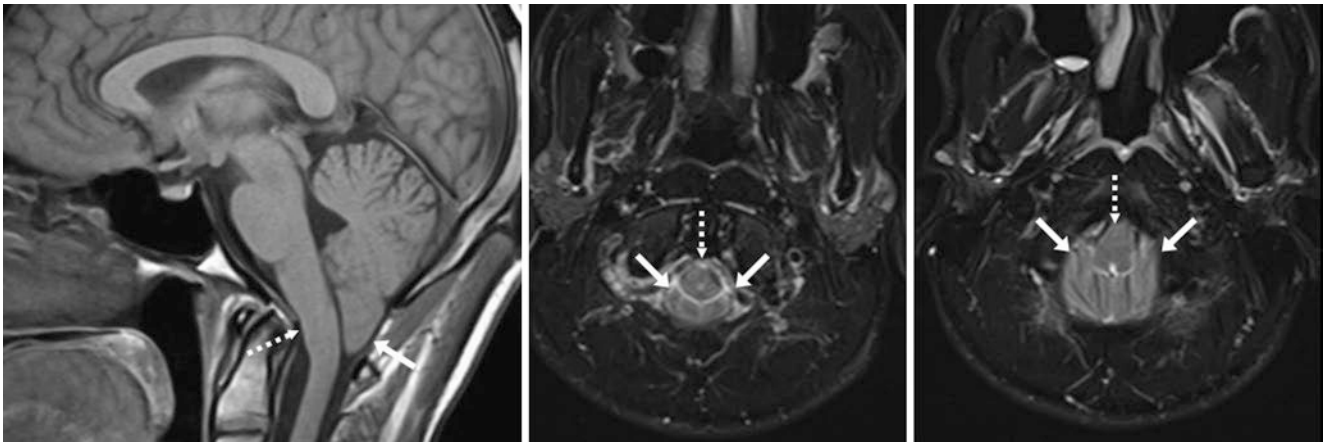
Comparison case of Chiari 1 malformation without syrinx. A 26-year-old patient with tussive headaches had 11 mm of tonsillar herniation (*arrows*) on a 1.5 T MRI with sagittal T1WI (*left*) and axial
